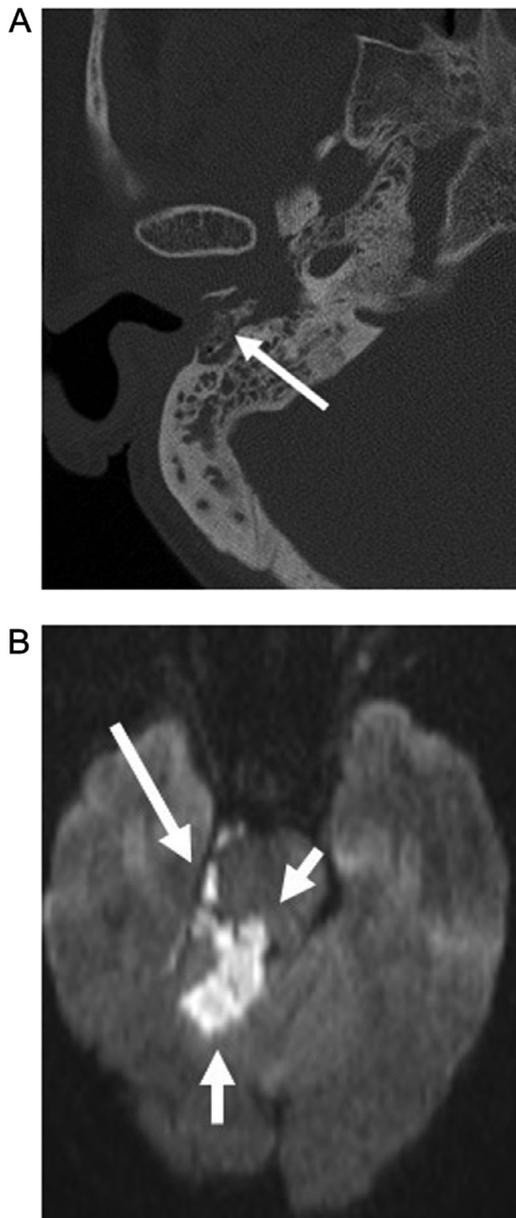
48f with NOE. Axial CT image (A) shows soft tissue in the EAC with erosion of the anterior and posterior walls and osseous fragments (arrow) in the EAC. DWI (B) shows increased signal within the perimesencephalic cistern consistent with extension of infection into the subarachnoid space representing meningitis (long arrow) and increased signal within the cerebellum and brainstem (short arrows) likely representing infarcts, presumably from vasculitis, and possibly areas of cerebritis.
